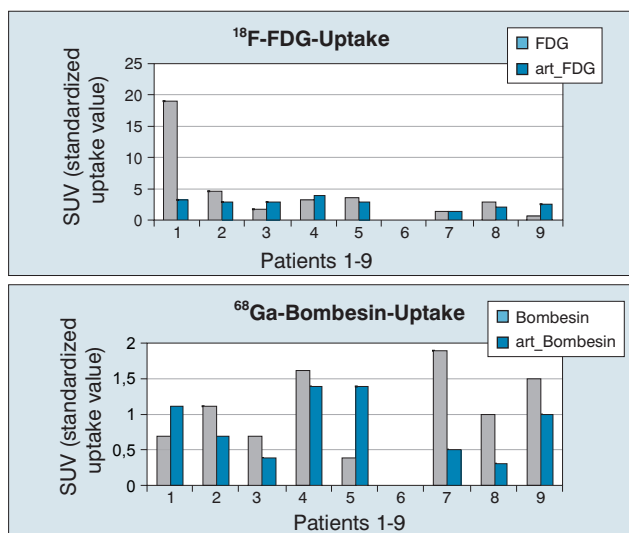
⁶⁸Ga-bombesin and ¹⁸F-FDG-uptake in the PET-examination.
